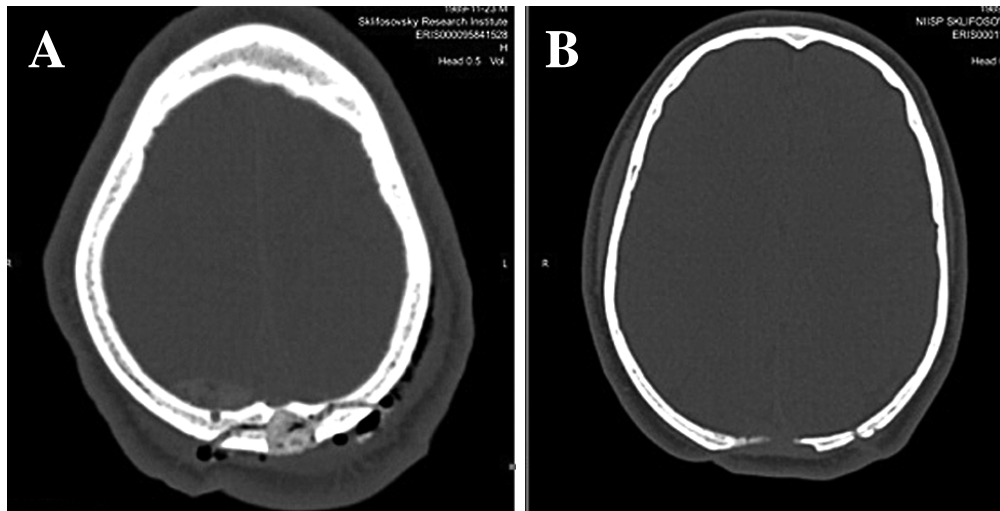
Computed tomography of the skull in the axial plane after osteoplastic craniotomy in the frontal region with using osteoplastic
